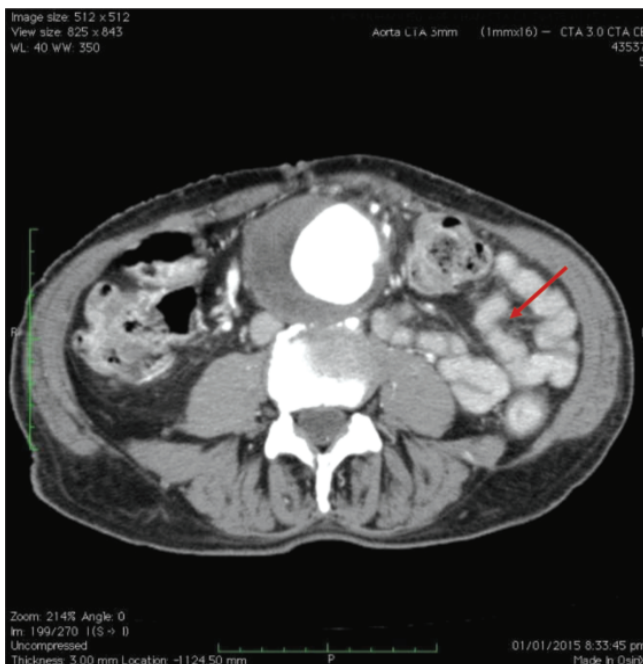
CT scan abdomen with contrast, arrow pointing toward filling of I/V contrast in the small bowel giving the impression of AEF.
